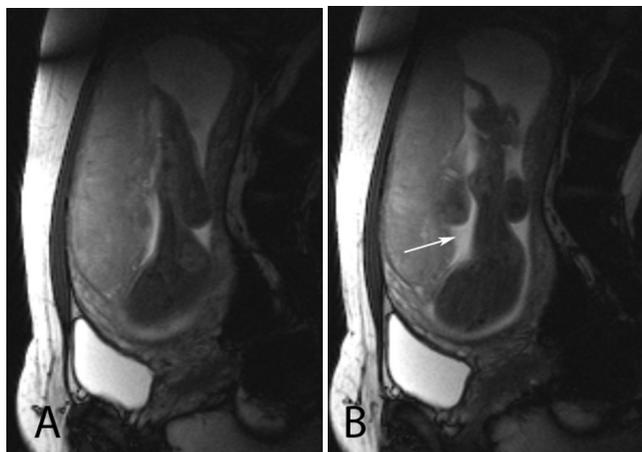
24-week-old fetal female with sirenomelia. Coronal T2 MR images demonstrate fused, abnormally positioned, fixed, and extended lower extremities (arrow).
